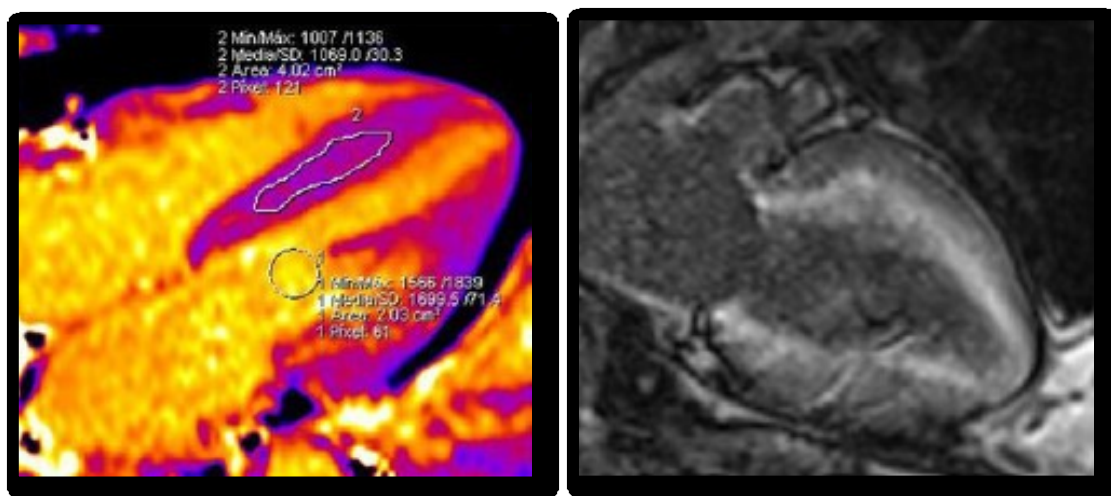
T1 mapping in amyloidosis. Nonenhanced four chamber MOLLI T1 map shows diffusely increased T1 values (Left). Two chamber LGE MR image shows subendocardial enhancement (Right).
